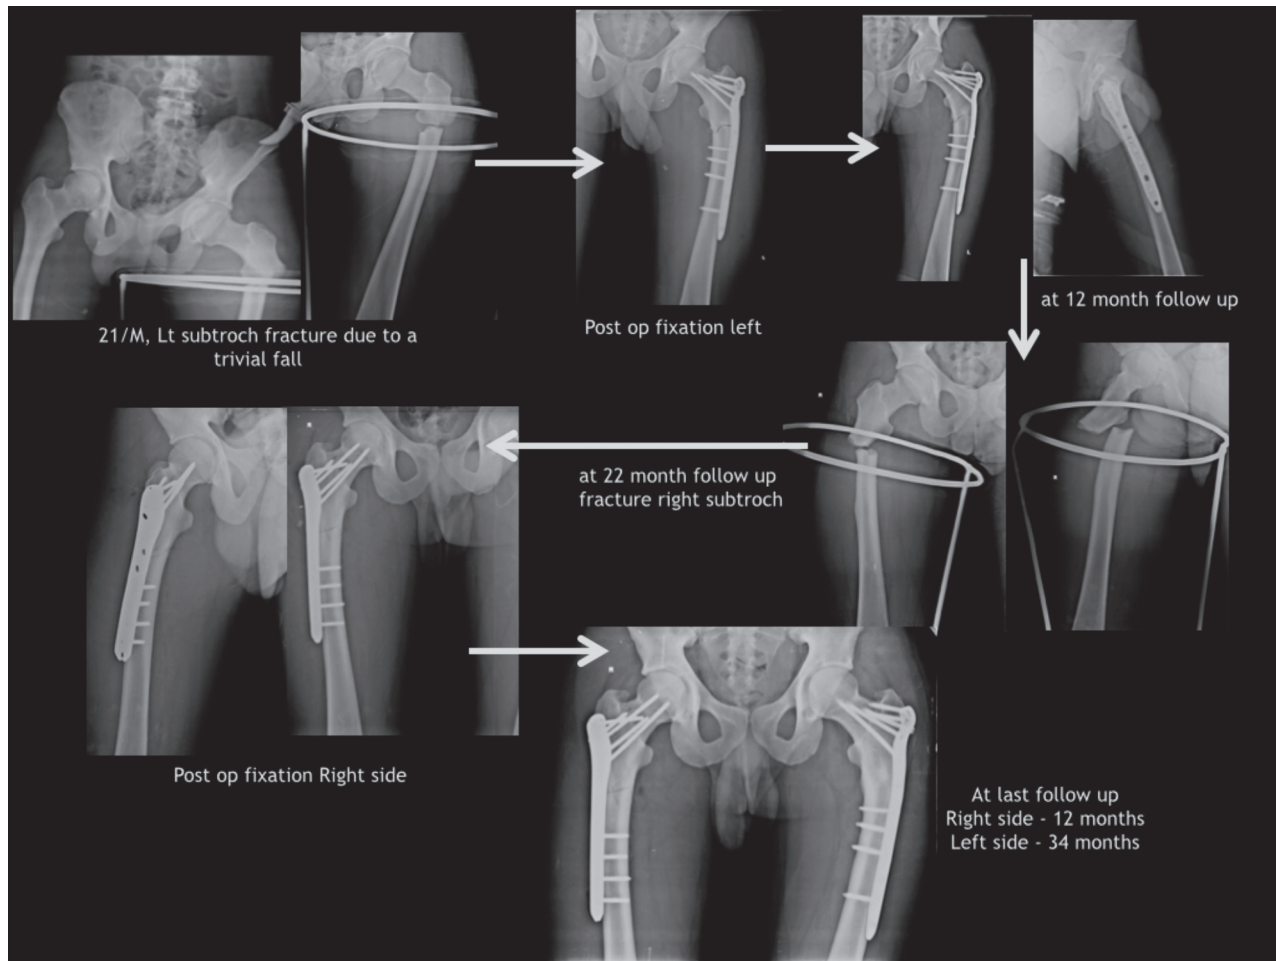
Radiographs of Patient 3 – managed for bilateral subtrochanteric fracture over 22 month interval.
